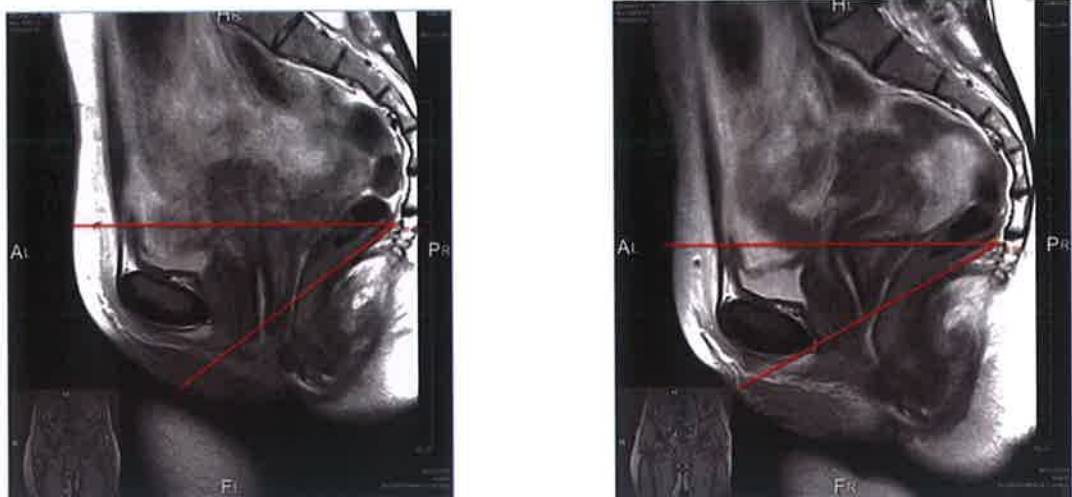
MRI before (left) and immediately after (right) treatment in single case study
